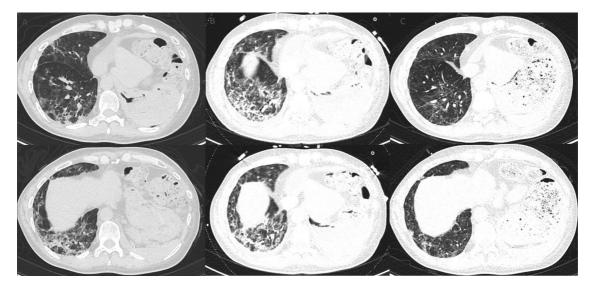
CT axial slices during the evolution of the case. (A *first column*) CT after treatment for CMV and intravenous immunoglobulin demonstrating new ground glass opacities along with consolidations and reticular opacities. (B *middle column*) Despite treatment for both CMV and PCP, CT image reveals worsening in pulmonary compromise. (C *third column*) CT demonstrating significant radiological improvement after CPT followed by substantial clinical improvement in a short period of time.
